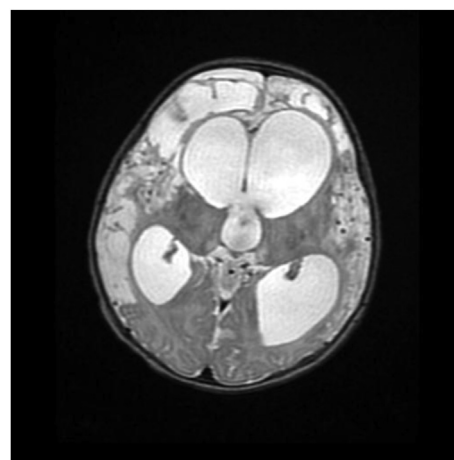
Head MRI image on day 21 showing marked ventricular enlargement and cerebral softening with necrosis, ✕MRI: magnetic resonance imaging.
